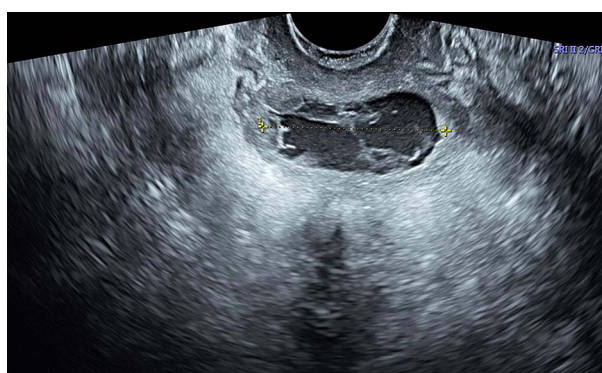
Grayscale ultrasound image showing a well-defined mass in the posterior vaginal wall (2020.05.25).
